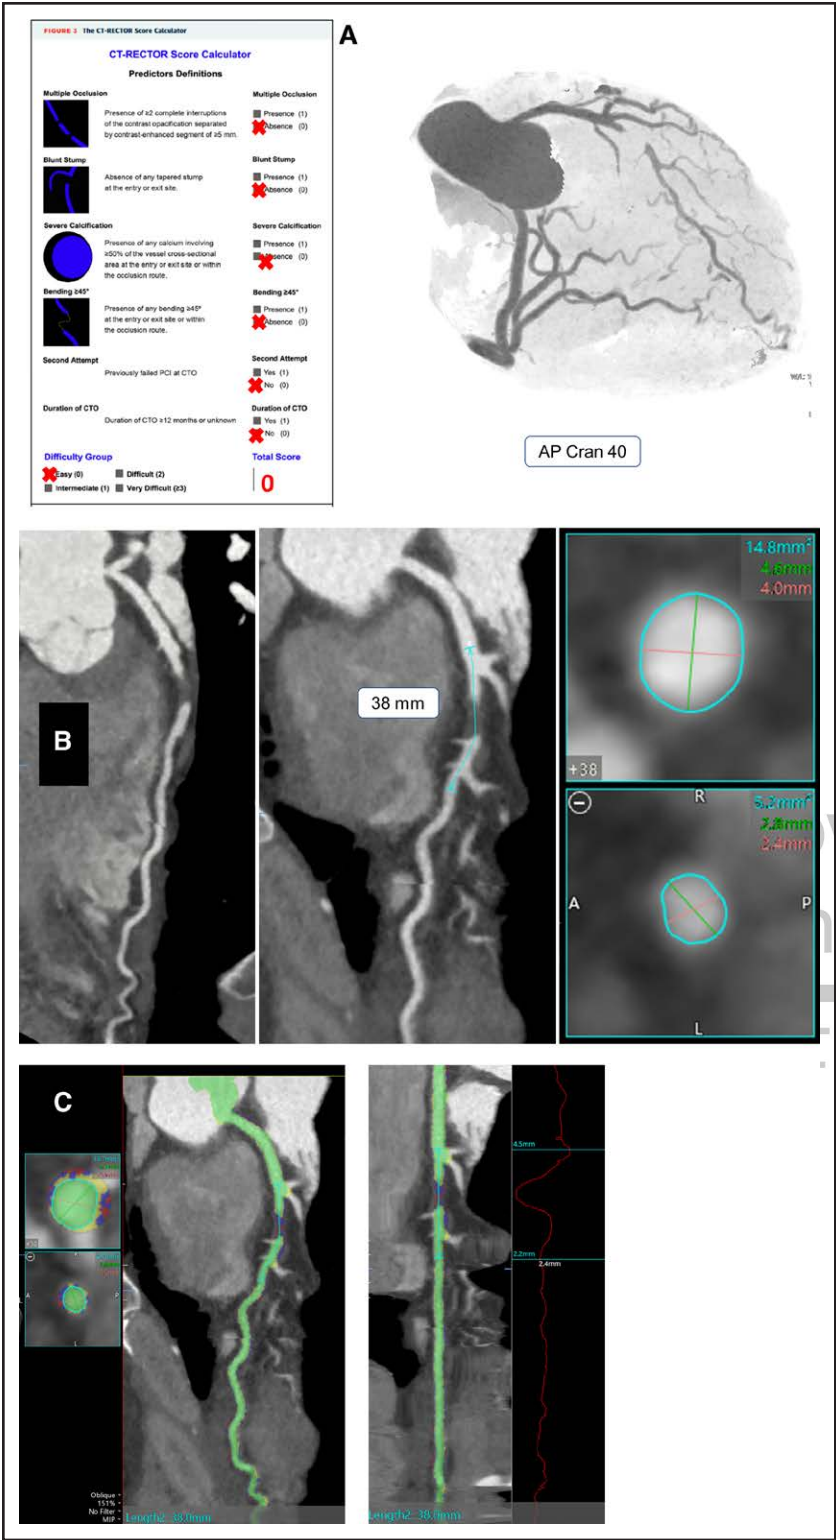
Example of coronary computed angiography for guiding CTO PCI. A, Maximum intensity projection of a coronary computed tomography angiography showing a mid-left anterior descending artery chronic total occlusion with a low CT-RECTOR score. B and C, Multiplanar reconstruction allowing estimation of stent length and diameter. There is no significant calcification. CT-RECTOR indicates Computed Tomography Registry of Chronic Total Occlusion Revascularization; and KCCT, Korean Multicenter CTO CT Registry.
